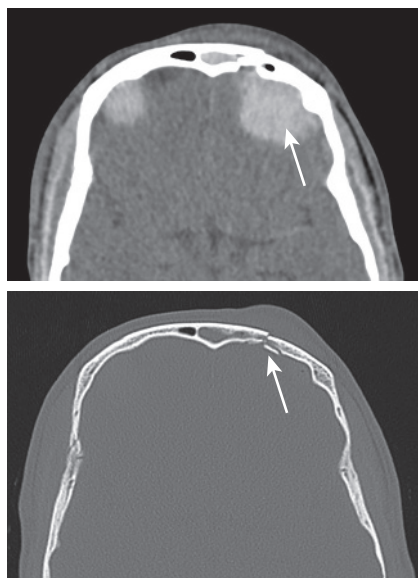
Axial reconstructions of a computed tomography scan of the brain demonstrating a left frontal extradural haematoma (*long white arrows*). Note the overlying comminuted and mildly depressed fracture of the left frontal bone (*short white arrow*).
